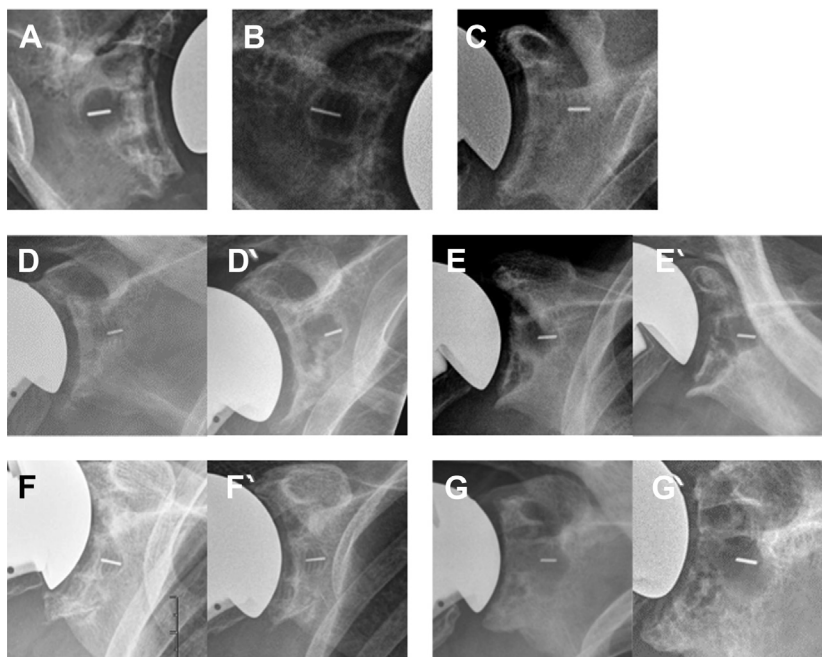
True anteroposterior (Grashey view) radiographs showing central-peg grading (CPG) scale for grade 1 (central-peg osteolysis [CPO]) (A), grade 2 (bone growth to edge of flanges) (B), and grade 3 (bone growth within flanges) (C). Example of CPG progression from grade 3 (D) to grade 1 (D'). Example of CPG progression from grade 1 (E) to worsening of grade 1 (E'). One should note the advancement of early sclerotic edges to radiolucency around the central and peripheral pegs (E'). Example of early radiograph showing grade 3 (F), with no change in CPG (ie, stable grade 3) (F'). Example of stable early grade 1 CPO (G), with no progression of CPO and a stable peripheral peg appearance (G').
